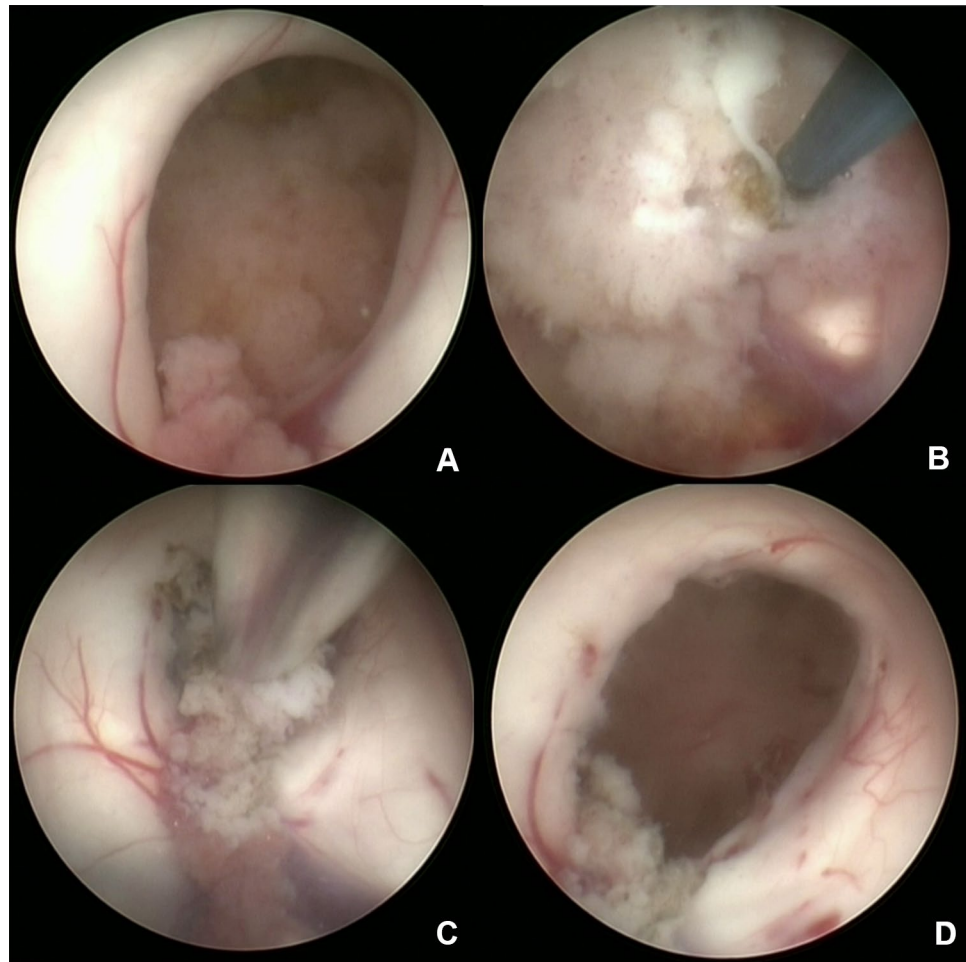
Intraoperative images of case 2. A Appearance of the papilloma behind the foramen of Monro, with its typical cauliflower appearance. B Coagulation of the surface of the tumor. C Ultrasonic debulking of the tumor. D Complete removal of the tumor
